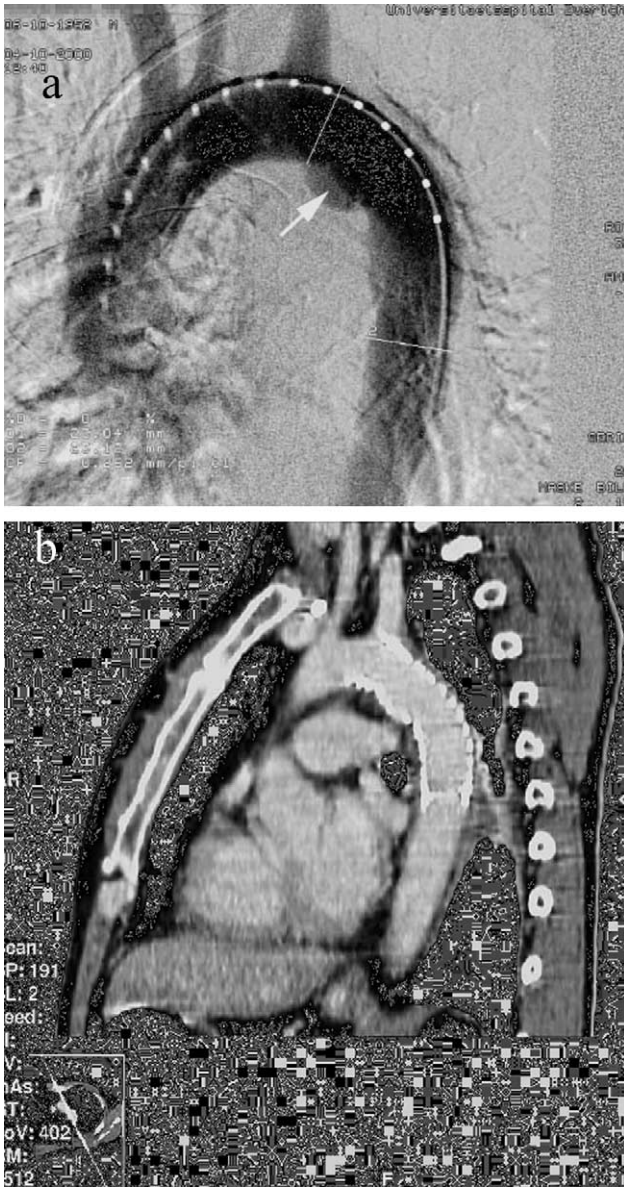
(a) Intraoperative angiography of traumatic aortic rupture at level of aortic isthmus after blunt chest trauma. The arrow shows the point of aortic rupture. (b) CT scan performed directly after stent-grafting. There is no leak that can be detected. Reconstruction shows a satisfactory proximal anchorage
